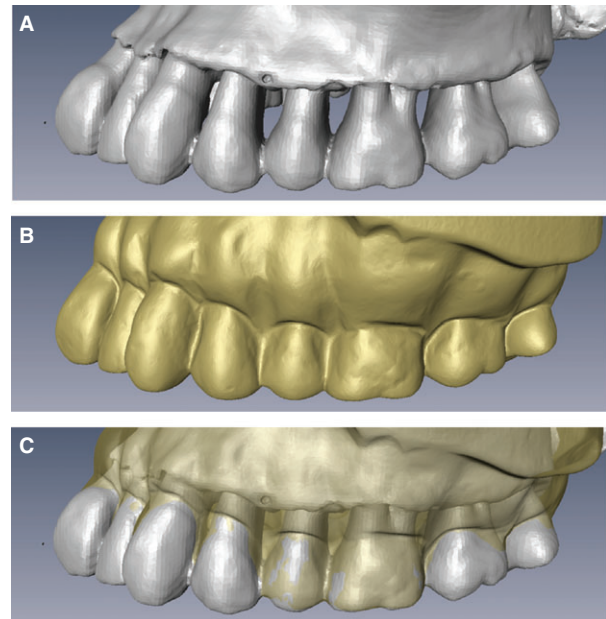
Example of digital bone sounding; the relationship between the bone level and the soft-tissue contour can be clearly visualized. (A) Reconstructed three-dimensional maxilla from multislice computed tomography scanning. (B) Three-dimensional virtual maxillary arch model generated by surfacing scanning. (C) Superimposition of the virtual three-dimensional models clearly outlines the soft-tissue volume.
